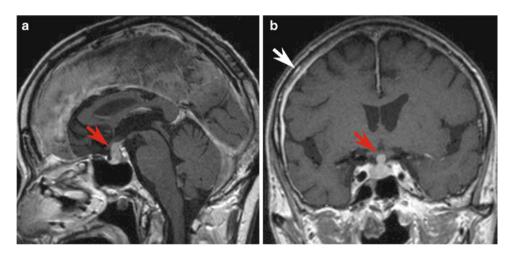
MR images of IgG4-related hypophysitis and hypertrophic pachymeningitis. (a) Sagittal section and (b) anterior section. Swelling is found from the pituitary anterior lobe to the pituitary stalk. The entire
